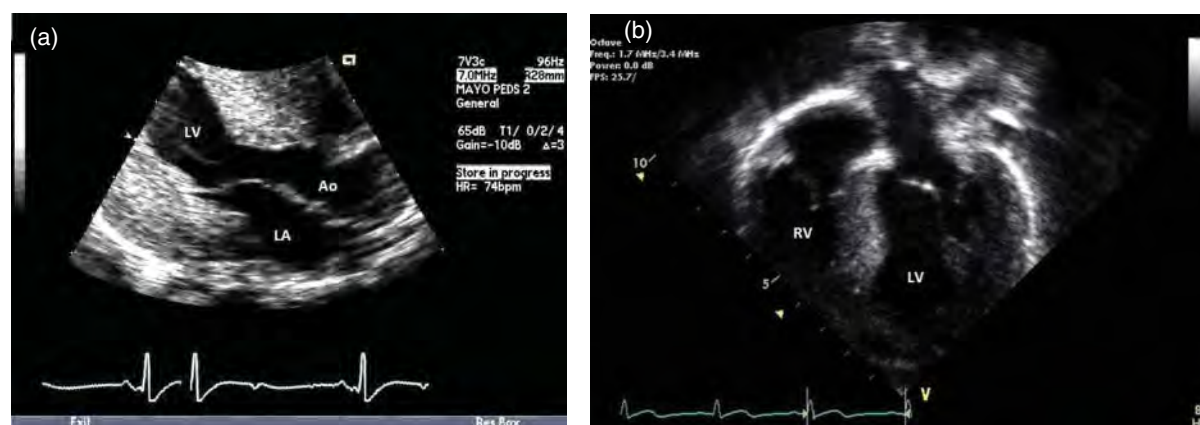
Echocardiograms of Noonan syndrome with left ventricular hypertrophy (LVH). (a) Parasternal long-axis and (b) apical four-chamber views of patient with (genotype negative) Noonan syndrome and LVH showing moderately increased concentric left ventricular wall thickness with maximum left ventricular wall thickness of 11 mm. There are no signs of pulmonary stenosis, valve abnormalities, or atrial or septal defects.
